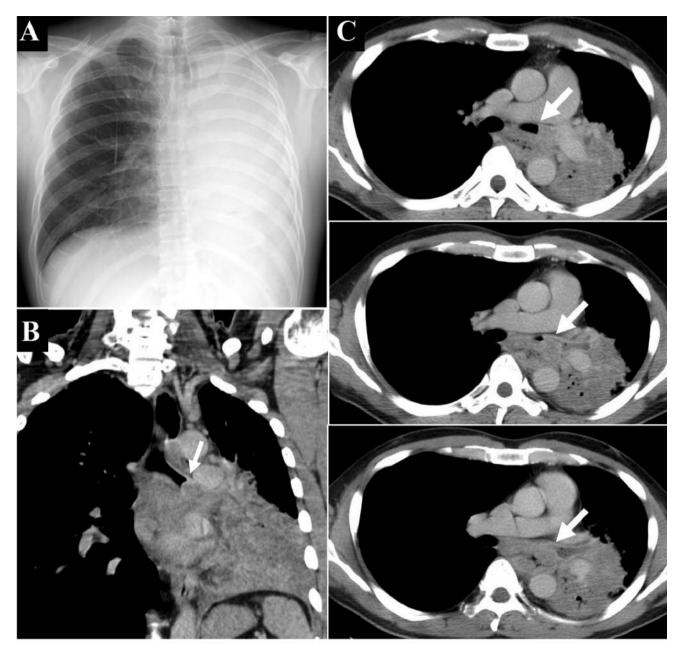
A: Chest X-ray showing extensive atelectasis of the left lung. B and C: Computed tomography imaging showing locally advanced esophageal cancer with invasion to the left main bronchus (arrow).
